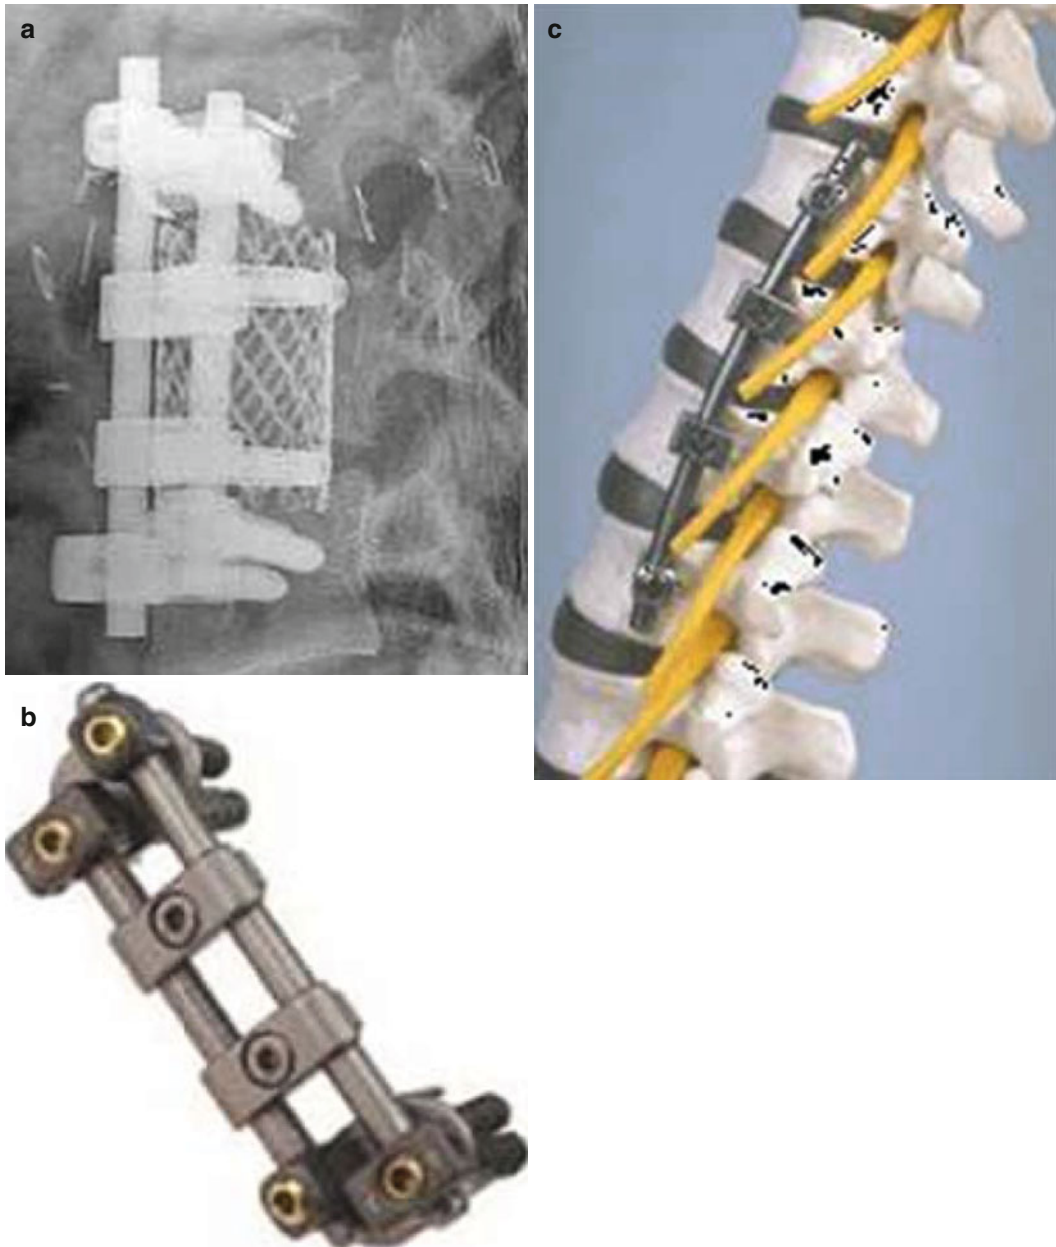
(a) The image shown here is a radiograph of an interbody cage with supplemental anterior stabilization with bilateral rods and screw fixation. Note the trajectory of the screws within the vertebral bodies. There are additional cross bars interconnecting the two rods. (b) The
